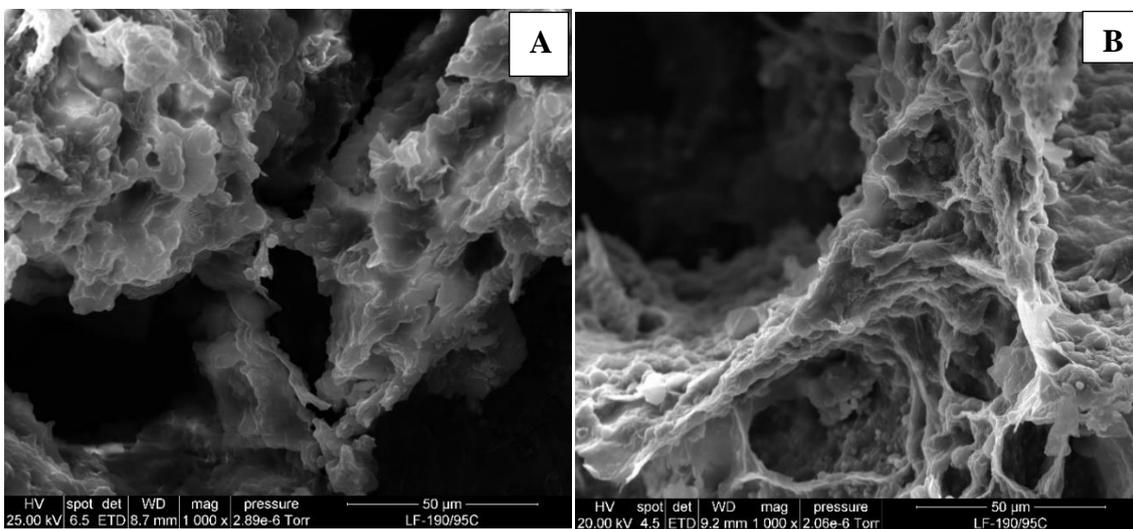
SEM images of spent HSMs after ultrasound-assisted extraction at 65 °C and pH 9 using ultrasound at (A) 20% amplitude and (B) at 80% amplitude.
